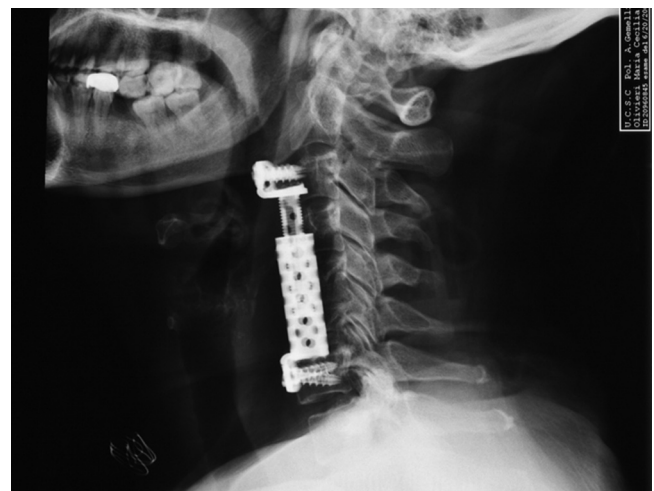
X-ray performed one week 1 after first operation (the patient complained against dysphagia) showing superior hardware dislocation (pull out the cranial screws with anterior removal of C3 body).
